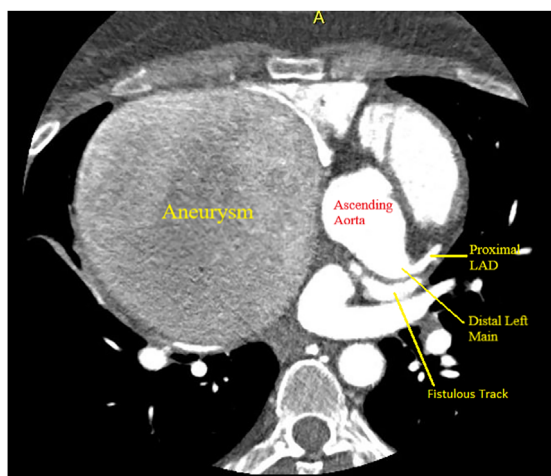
Computed tomographic chest scan demonstrating aneurysmal dilatation of left main coronary artery with a fistulous tract overlying the dome of the left atrium. LAD, left anterior descending
